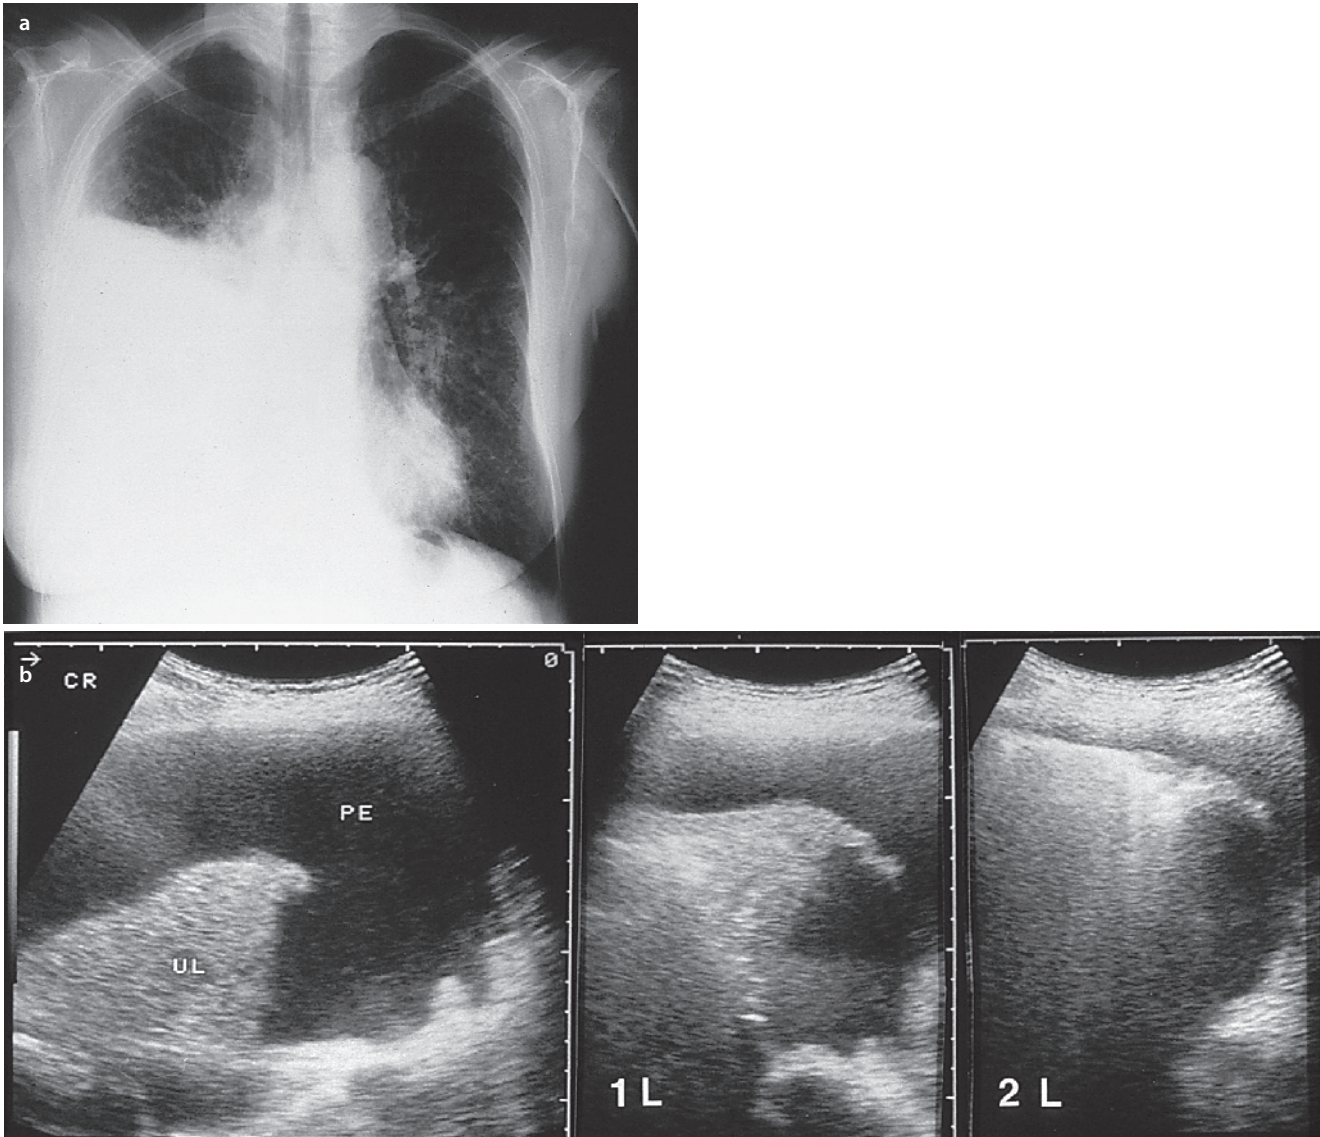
A 66-year-old man with an alveolar carcinoma. a Chest X-ray: homogenous shadow of the caudal right-sided hemothorax. b Sonography: right-lateral intercostal echo transmission shows a
